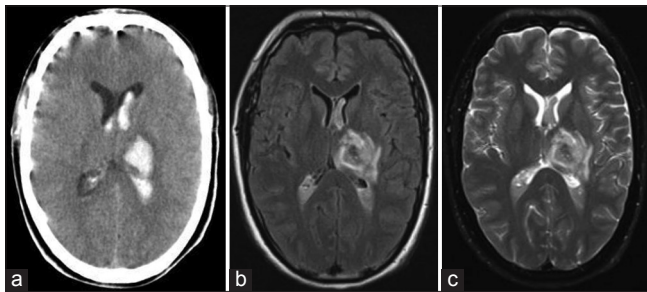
Initial head computed tomography (a: Axial view) and brain magnetic resonance imaging (b: Axial T1-weighted; c: Axial T2-weighted) show a left thalamic intracerebral hemorrhage with ventricular extension and no discernible flow voids to suggest an arteriovenous malformation
